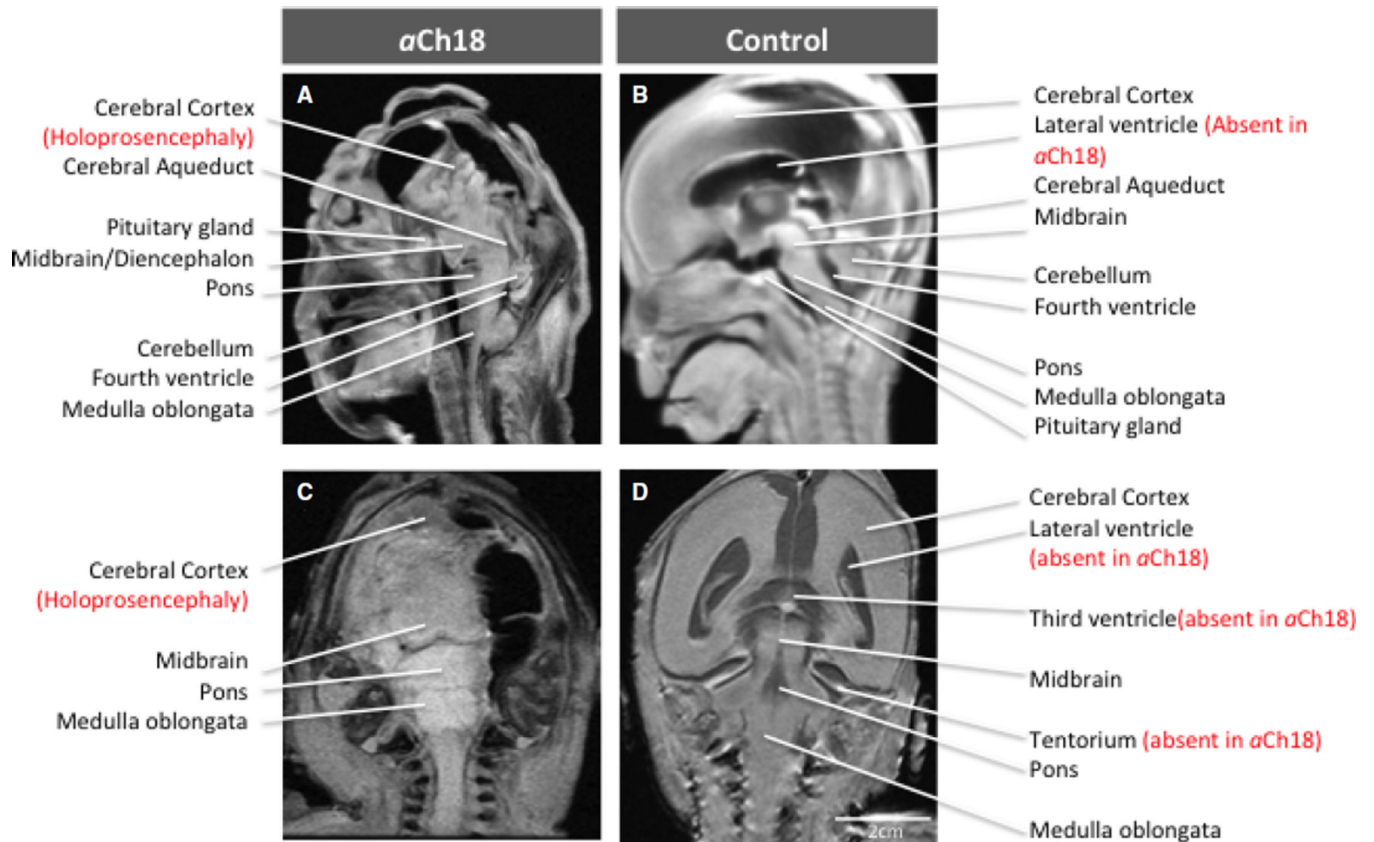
MRI phenotypic presentation of HPE in individual brain structures. (A) Sagittal view of HPE brain in aberrant Ch18 (*aCh18*), with features of anencephaly, absent anterior cranial fossa, and upright, enlarged brainstem structures. The control fetus (B) has a fully induced forebrain and well-developed lateral ventricle, which are both missing in *aCh18*. Coronal slice of *aCh18* showing missing brain tissue on the right and lack of separation in the lobes (alobar). (D) The control for (C) exhibits the ventricles missing in *aCh18*, and the classic morphology of the brainstem.
